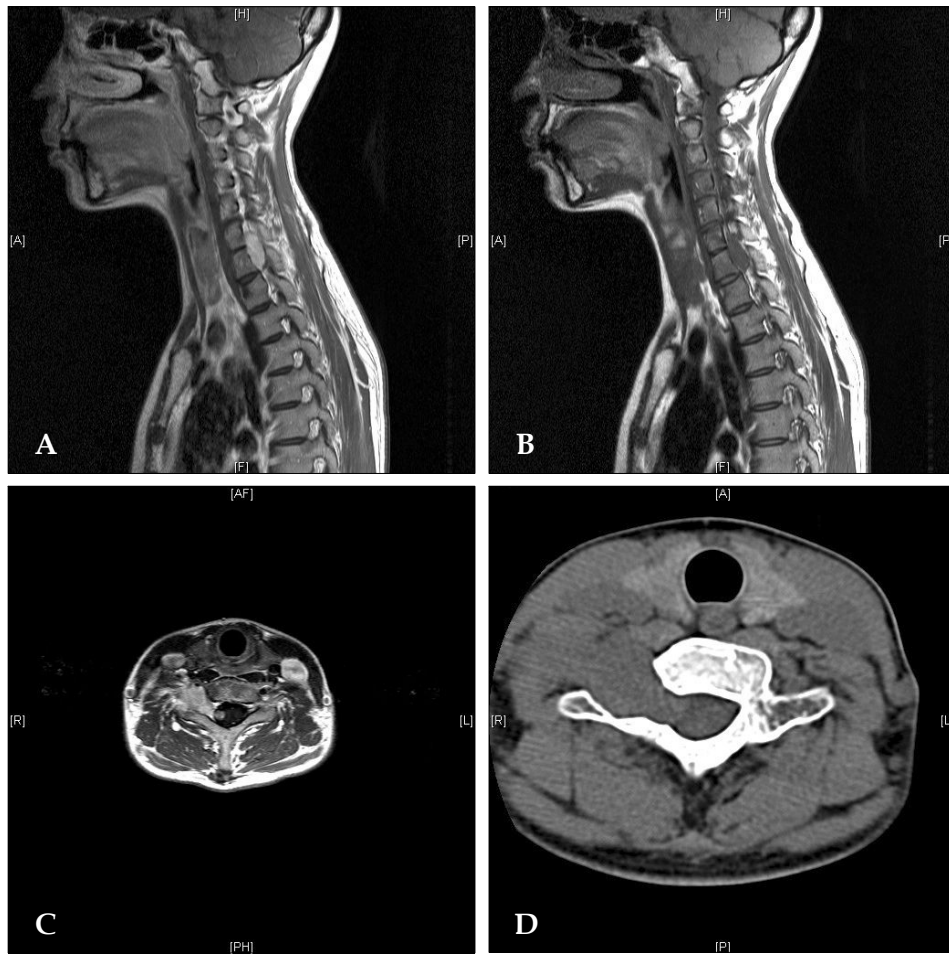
Preoperative magnetic resonance images and computerized tomographic scan showing a dumbbell-shaped, extramedullary, extradural mass with homogenous enhancement at C6-7. A: Sagittal, T2-weighted image showing a hypointense mass behind C6 and C7 vertebral bodies. B: Sagittal, T1-weighted image showing isointense mass. C: Axial, T1-weighted-gadolinium-enhanced image showing a homogeneously enhanced mass, located mainly in the extradural space with foraminal extension and partly in the intradural extramedullary space. D: Computerized tomographic scans showing enlarged, right C6-7 neural foramina.
